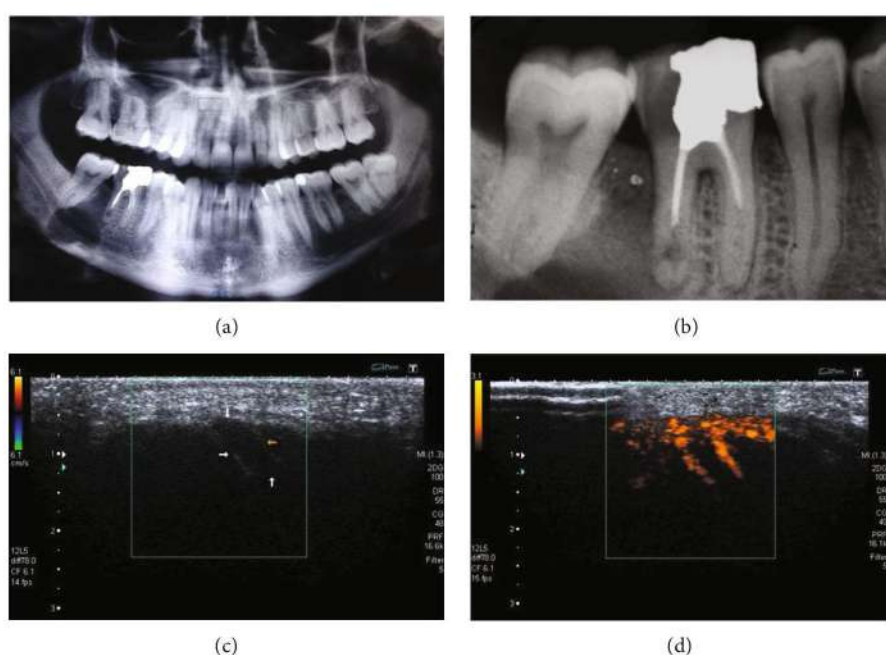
Images of the 27-year-old patient presenting an extensive asymptomatic lesion of the right posterior mandible. (a) The panoramic radiograph shows a well-defined unilocular osteolytic lesion with sclerotic margins located between the two molar teeth and superimposed on the alveolar inferior nerve. (b) The periapical radiograph of the first molar depicting inadequate root canal treatment with signs of perforation in the apical third of the distal root involved in the osteolytic lesion. (c) B-mode ultrasound examination showing a transonic lesion (arrows). (d) Power-Doppler image showing the presence of peripheral vascularity.
